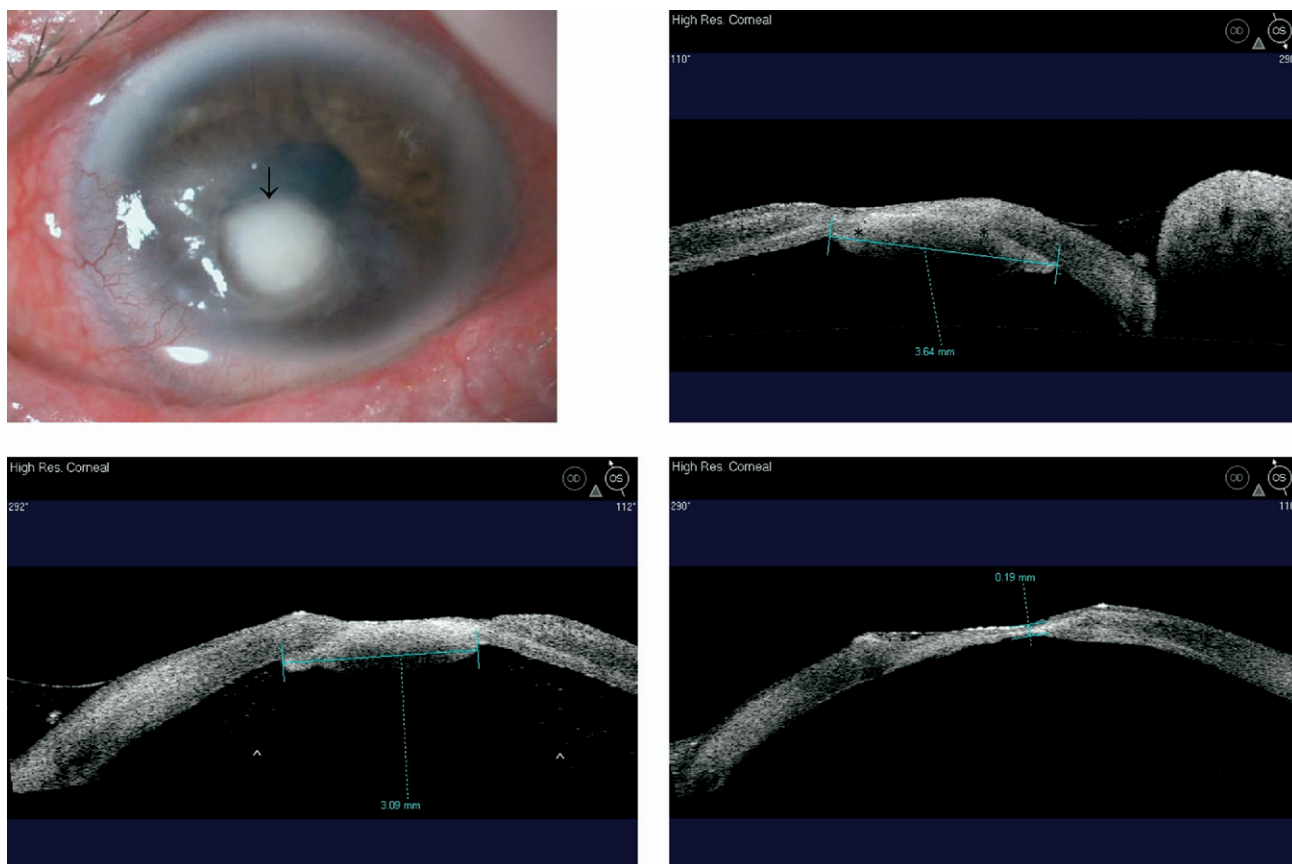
Images demonstrating microbial keratitis in a patient with trichiasis and lagophthalmos, including serial high-resolution AS OCT images at the 110-degree meridian. (Top left) Anterior segment photograph obtained at presentation showing corneal infiltrate (arrow). (Top right) AS OCT image obtained at presentation showing sloping ulcer edges with corneal thinning and a plaque of organized inflammatory cells attached to the endothelium (*). (Bottom left) AS OCT image obtained three days after initiation of treatment showing reduction of the inflammatory plaque width. Individual inflammatory cells (^) can be seen in the AC. (Bottom right) AS OCT image obtained 10 days after initiation of treatment showing resolution of inflammatory plaque; CT can now be measured.
